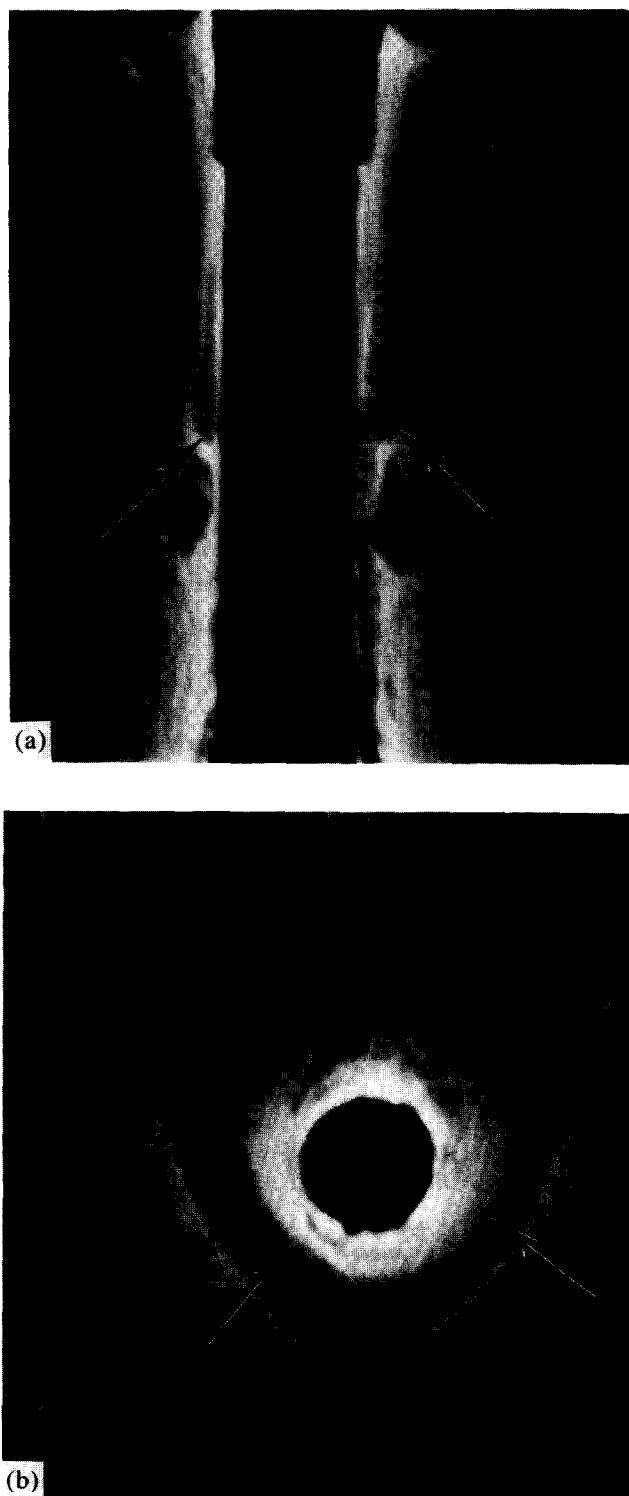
MRI of the anus using an internal coil. Excellent anatomical detail is seen in the coronal (a) and transverse (b) planes. The internal sphincter is clearly visible (arrows).
